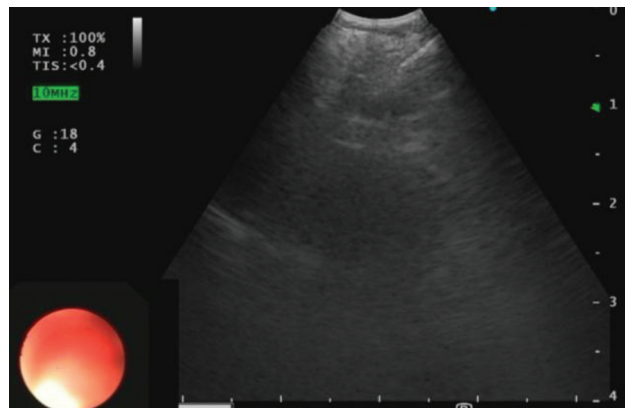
Endobronchial ultrasound image demonstrating transbronchial needle aspiration from subcarinal lymph node.
